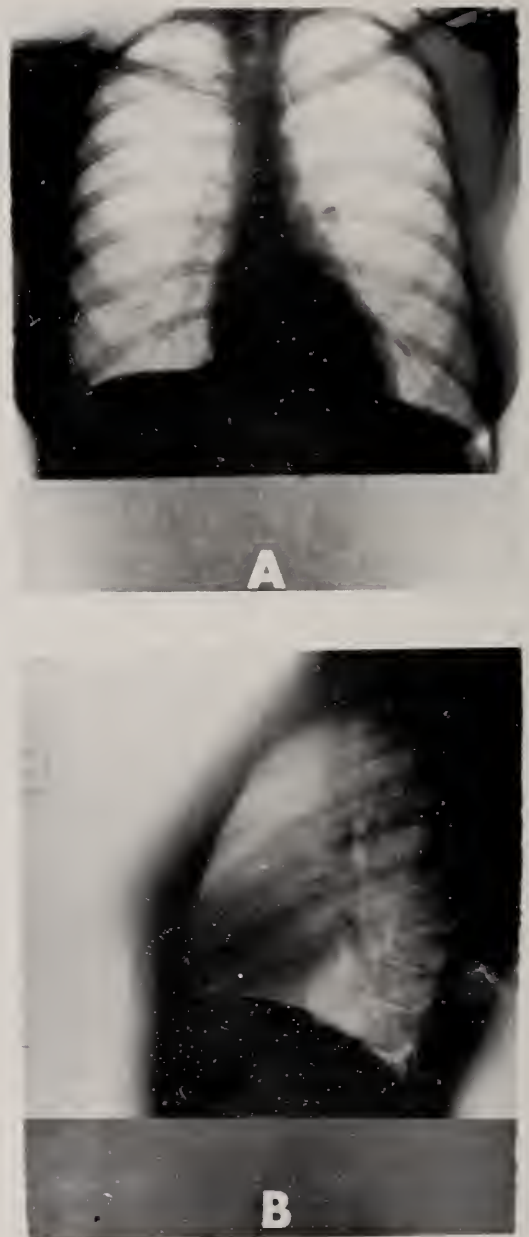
Case 1. A, B - September 1970. A-P and lateral chest x-ray showed a normal heart without evidence of pleural or pericardial effusions, venous congestion or infiltrates.
